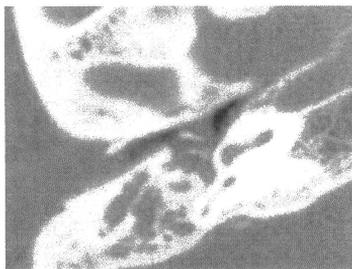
Computed tomography on April 17, 2008 showed a soft tissue shadow occupying the middle ear and mastoid cavity.
